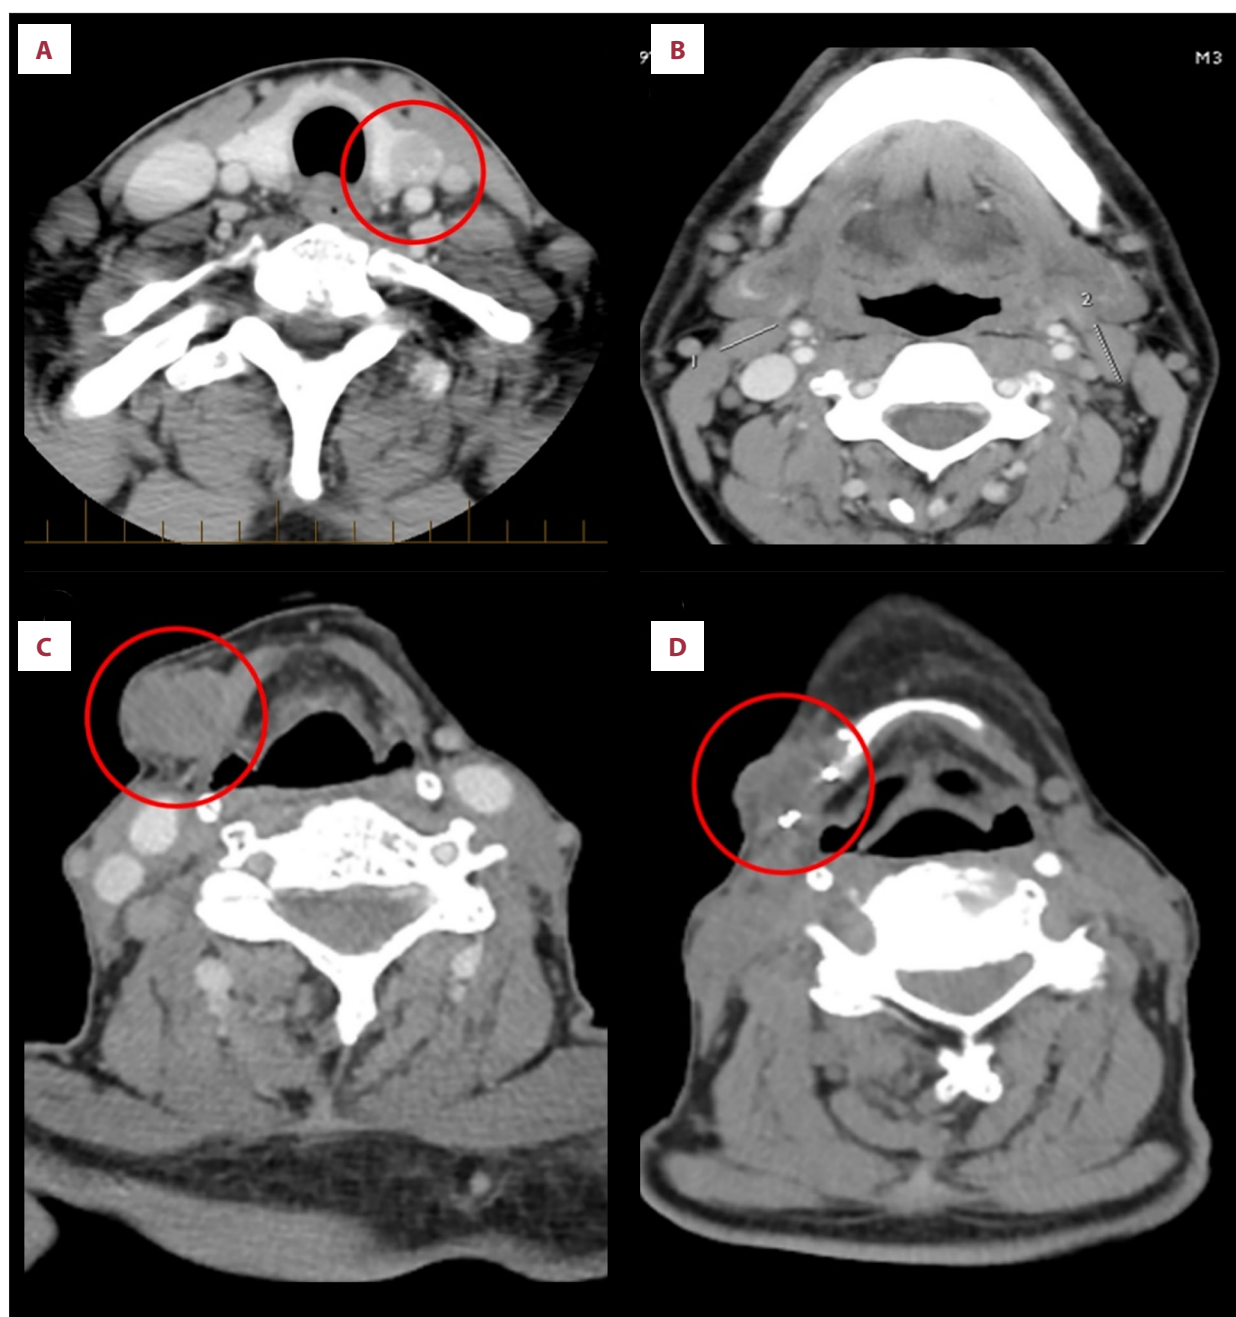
CT imaging showing the progression of neck soft tissue masses. In 2002, a 12-mm nodule was identified in the left thyroid lobe (A), along with multiple bilateral nodes suggestive of metastases, the largest in the jugulodigastric and right omohyoid regions measuring 16 mm (B). Images from 2025 after remission reveal a well-defined 1.9 × 1.7 × 1.5 cm lesion inferior to the right submandibular space, suspected enlarged lymph node with extracapsular extension (C). Postsurgical imaging shows resection of a right cervical sarcomatous mass between the right hyoid and thyroid cartilages (D).
